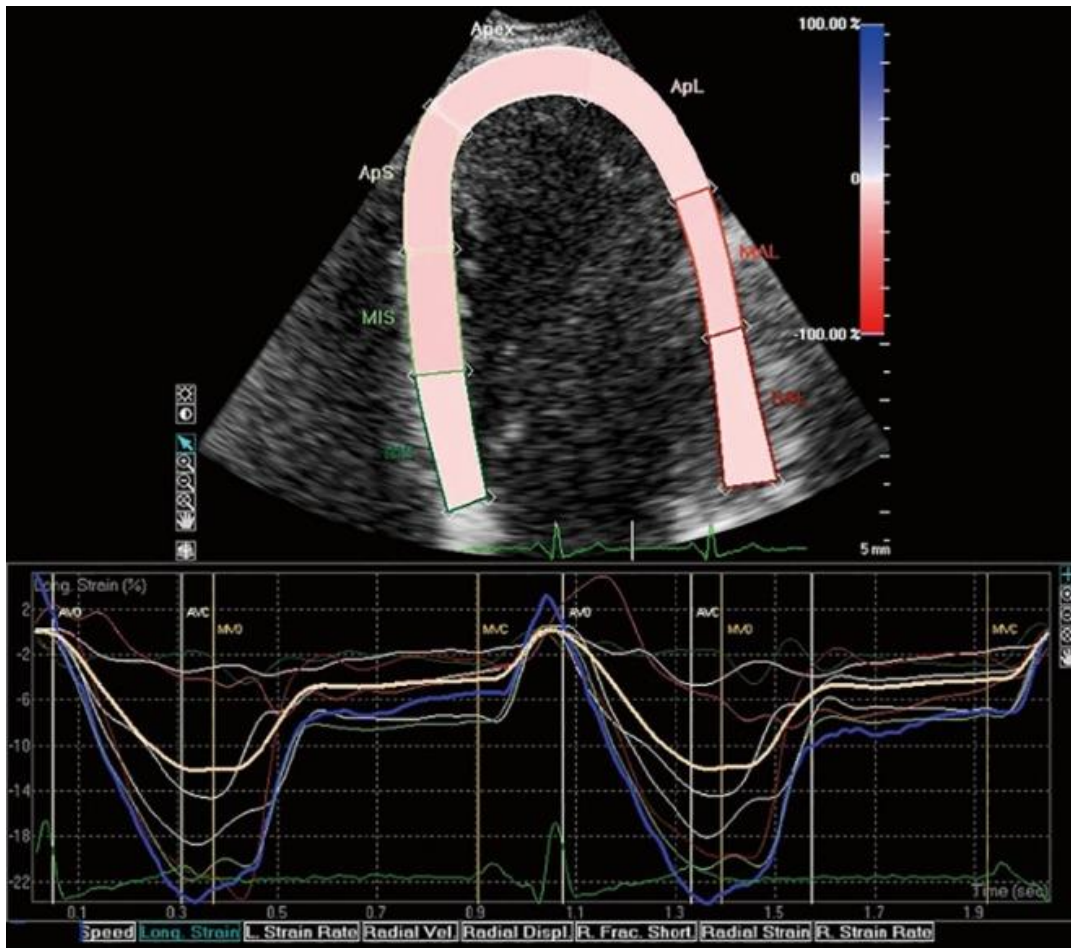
Left ventricular longitudinal strain determination and an apical 4-chamber view of a transthoracic echocardiography utilizing speckle tracking imaging. TTE, transthoracic echocardiography ⁽¹²⁾.
